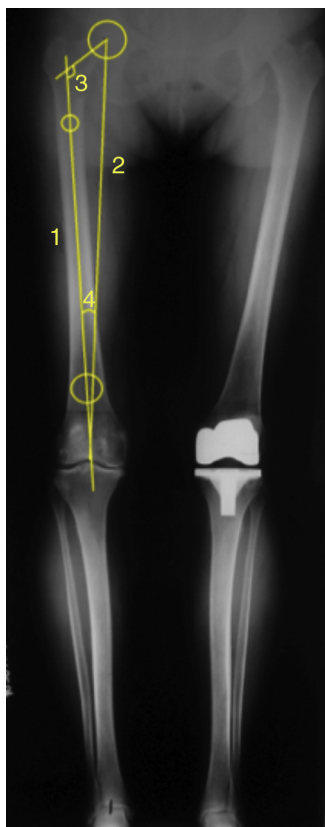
Panoramic radiograph of the lower limbs. (1) Femoral anatomical axis. (2) Femoral mechanical axis. (3) Cervicodiaphyseal angle. (4) Ideal femoral valgus.
